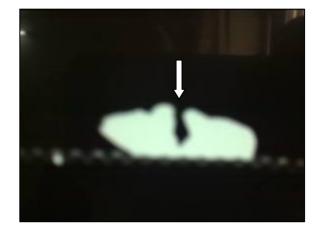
The site of osteotomy identified by CT scan and density measured in five points in site of osteotomy, and its means calculated.
